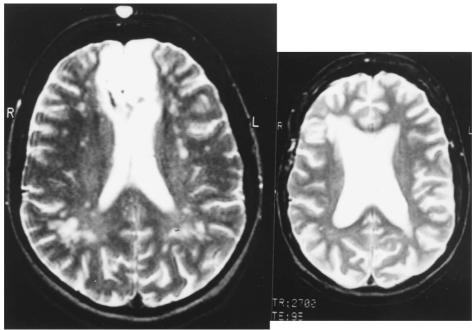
Axial MRI views of patients with (a) bilateral and (b) right unilateral focal frontal lesions (both vascular).
